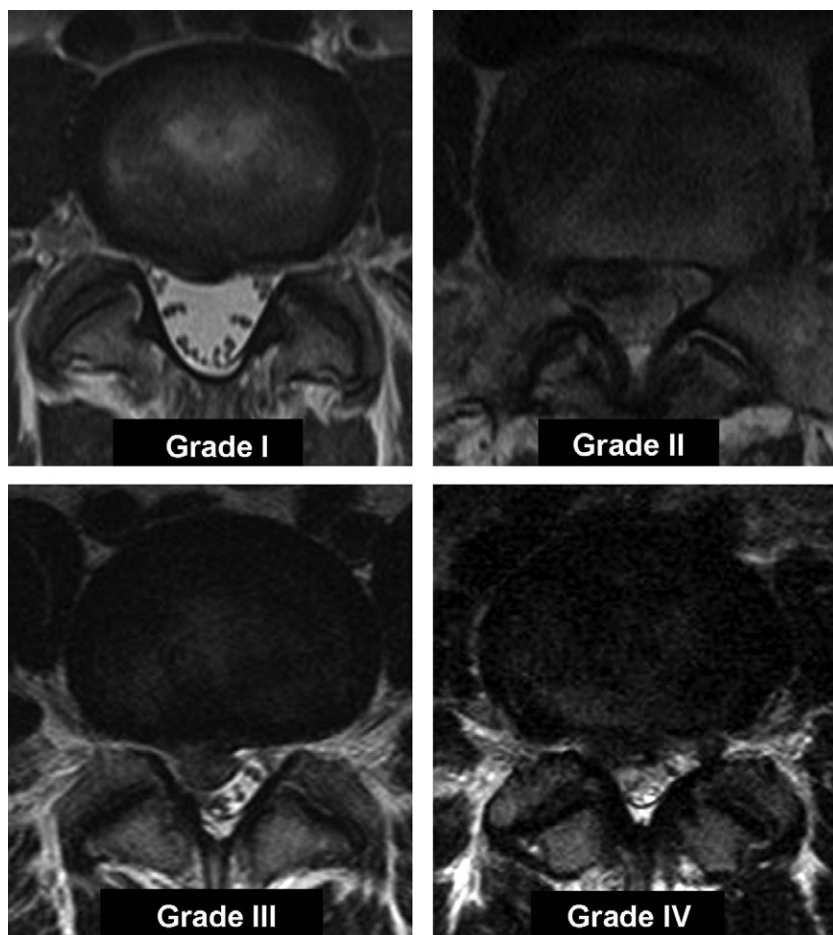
Axial magnetic resonance images showing examples of different grades of nerve root compression, as seen and as interpreted in the present study.
